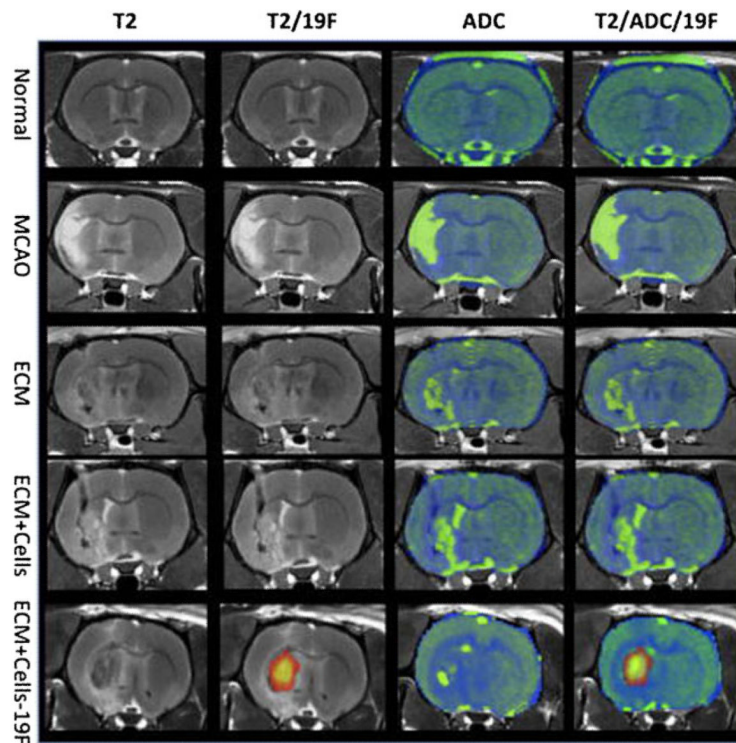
Ex vivo ^{19}F and diffusion MR imaging. A middle cerebral artery occlusion induces a hyperintense signal on a T2-weighted MR image compared to a normal control. In the absence of ^{19}F -labeled cells, no signal is detected on the ^{19}F scan. The apparent diffusion coefficient (ADC) image shows an increase in diffusion in the area of stroke infarction. Injection of extracellular matrix (ECM) derived from decellularized tissue affects both the hyperintense T2-weighted signal and the diffusion scan. On the T2-weighted image, the lesion cavity almost completely disappeared, although the ADC image still exhibits areas of high diffusivity. Only ^{19}F -labeled cells can be detected using the ^{19}F channel. It is evident here that injection of the ECM and ^{19}F F-labeled cells extensively cover the lesion cavity. Transplantation of unlabeled cells with the ECM did not significantly affect the ADC compared to injection of just ECM, indicating that the ECM was primarily responsible for significant changes in the lesion cavity's characteristics. (Reproduced from Ref. 86, with permission)
